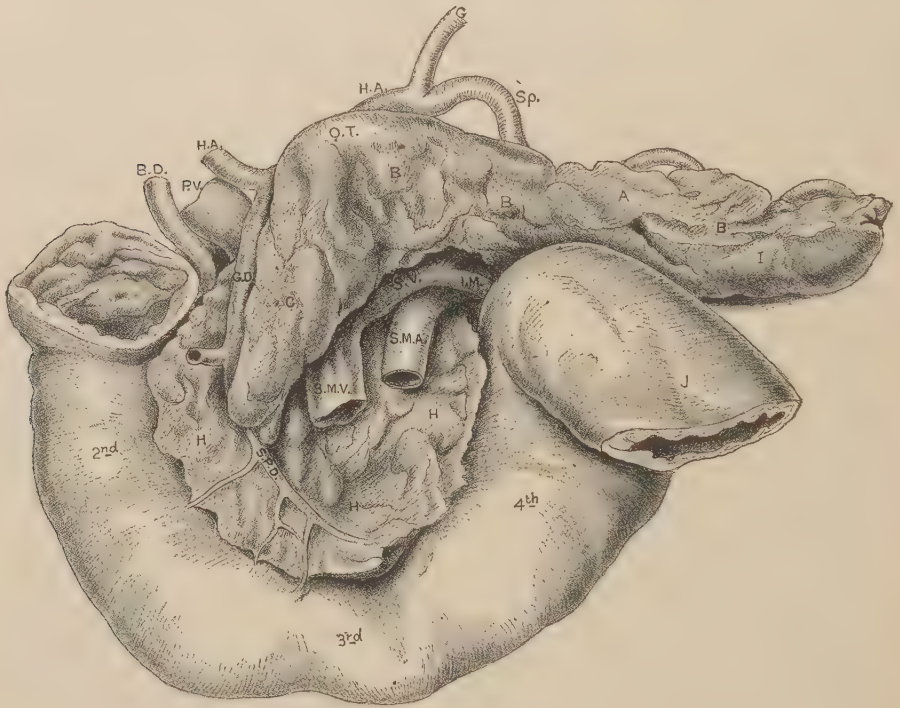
ANTERIOR ASPECT OF THE PANCREAS, ETC. (J. Symington.)
